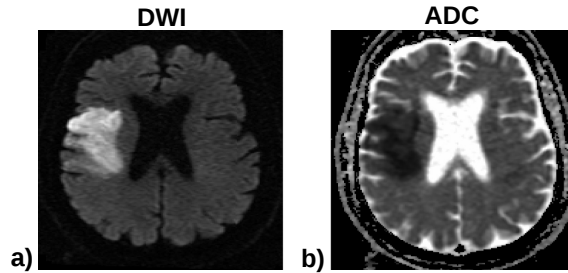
Diffusion-weighted imaging (DWI) of a patient with acute stroke (a) and the corresponding ADC map (b). The stroke affected area is shown bright on the DW image and dark on the apparent diffusion coefficient map. (*Figure taken from Birenbaum et al. (2011)*).
